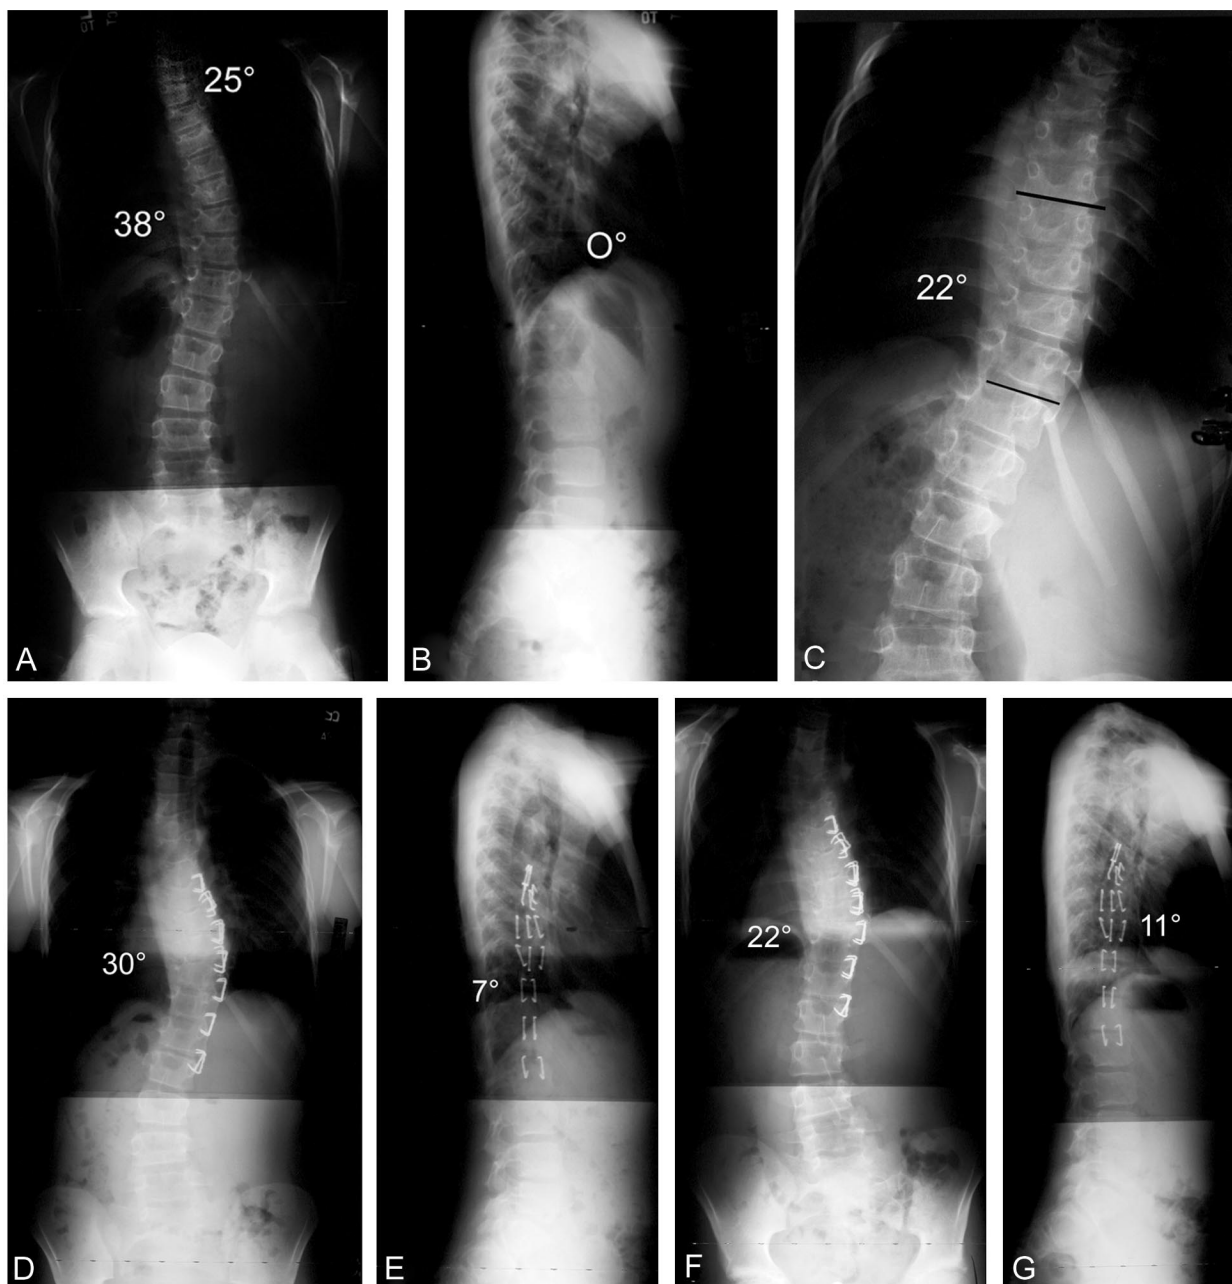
Case 1. A, Preoperative anteroposterior and (B) lateral in a 12-year-old male. He had been braced for adolescent idiopathic scoliosis for 2 years and had progressed from 25° to 38° and was considering a spinal fusion. He was Risser 0, with open triradiate cartilages. The lateral radiograph (B) shows 0° of thoracic kyphosis. The right supine bend (C) shows the curve to reduce to 22°. The patient underwent a vertebral body stapling from T7 to L2. The 1-year follow-up erect posteroanterior film (D) shows the thoracic scoliosis to be reduced to 30°. The lateral radiograph (E) shows the kyphosis to have increased to 7°. At 36-month follow-up, the patient's scoliosis reduced to 22° (F) and the thoracic kyphosis had increased to 11° (G). During the 36-month follow-up period, the patient grew 11 inches.
